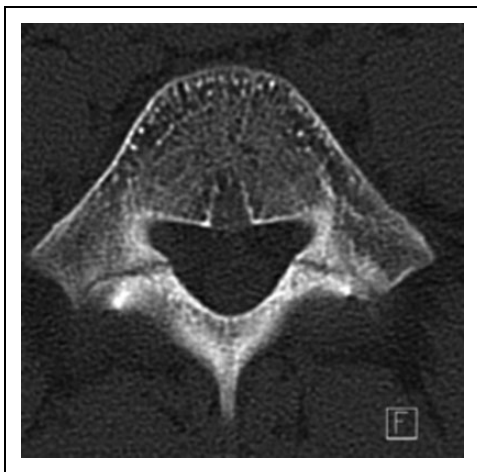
X-ray of the lumbar spine (axial view) showing bilateral spondylolytic defects. This radiograph is from one of the author's patients.
